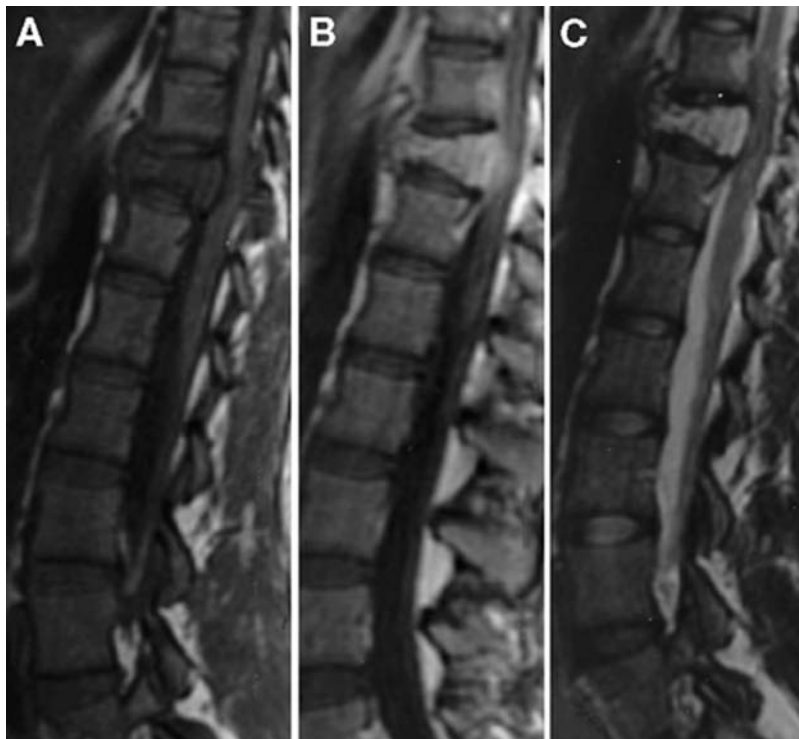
Sagittal MRI of T11 vertebral fracture with spinal cord compression due to vertebral hemangioma during pregnancy. Image A is T1-weighted image. Image B is gadolinium enhanced. Image C is T2-weighted. Reproduced with permission from Schwartz, T., Hibshoosh, H. & Riedel, C. Estrogen and progesterone receptor-negative T11 vertebral hemangioma presenting as a postpartum compression fracture: case report and management. *Neurosurgery* 2000; 46: 218–21.
